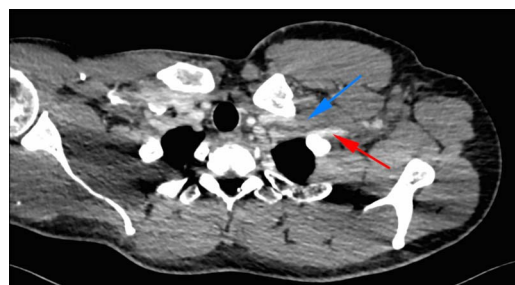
CT venogram axial slice. Blue arrow: occluded left subclavian vein. Red arrow: patent left subclavian artery.
